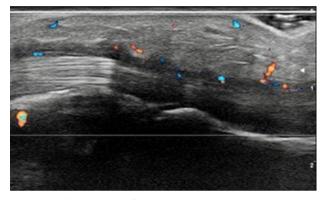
Flexor tendon of the second finger longitudinal section, centered on the proximal region, adjacent to MCF. Doppler signal localized peritendinous and in subcutaneous cellulose tissue.
